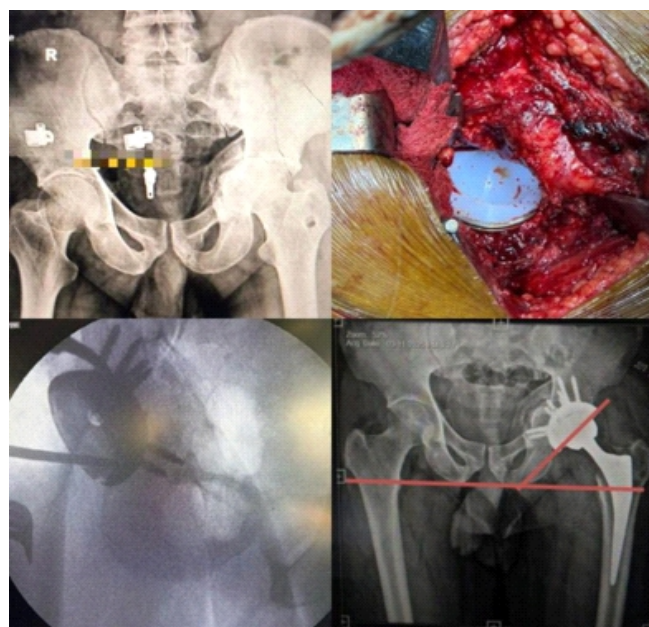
Case 2: Pre-operative, intraoperative and post-operative X-rays.
